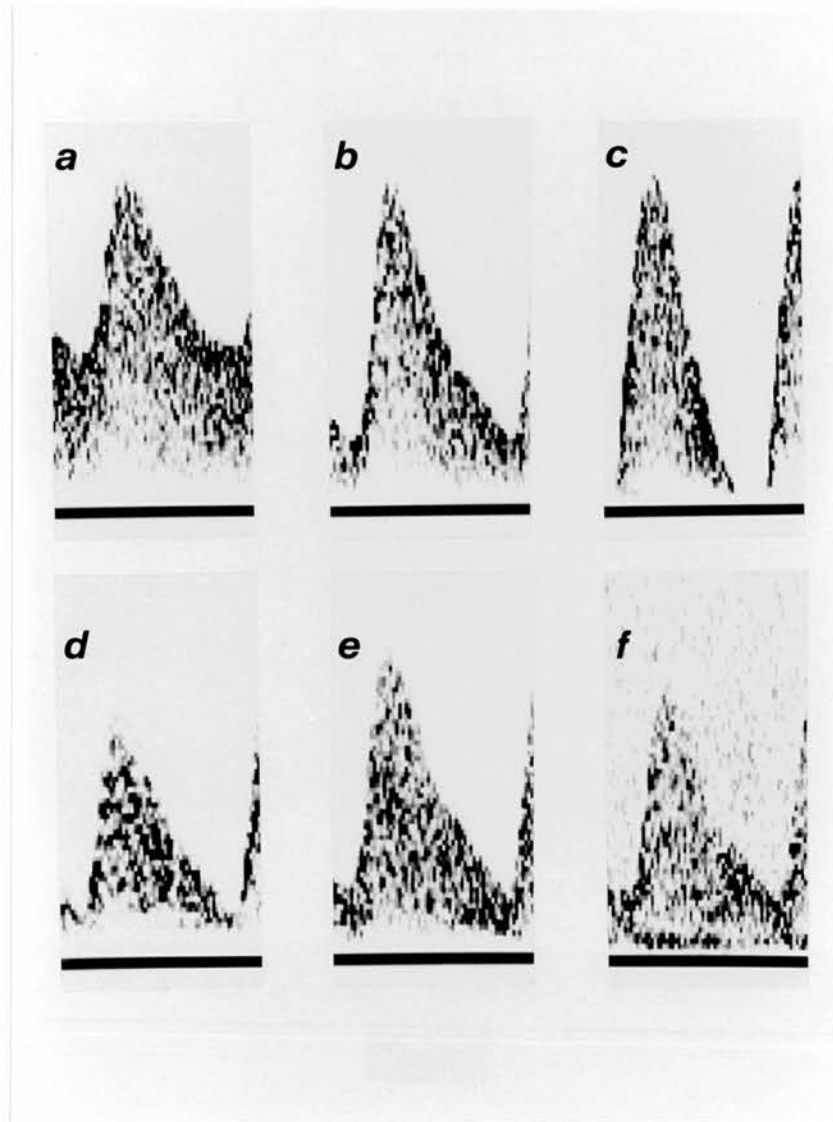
Doppler waveforms used for filter development. Waveforms are given in the table below; (θ is the beam-vessel angle, d is the transducer-vessel depth (cm), b is the beam-vessel axial offset (cm), a is the thickness of attenuating material between the vessel and transducer (cm), and RI is the resistance index).
